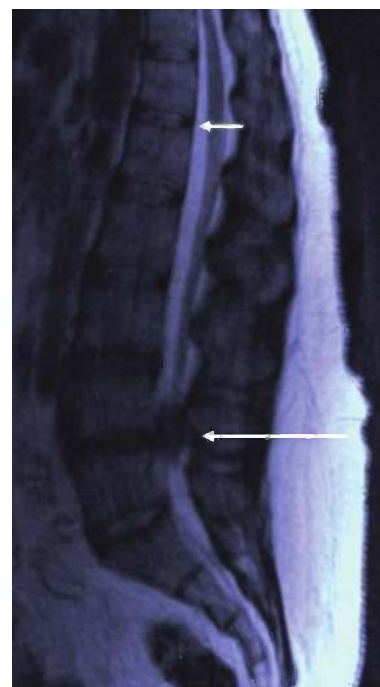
The MRI of the clinical case. There is herniation of the L4 disc with compression (large arrow) of the spinal nerve roots (cauda equina). The normal disc position at the T12 level is shown with the small arrow.
